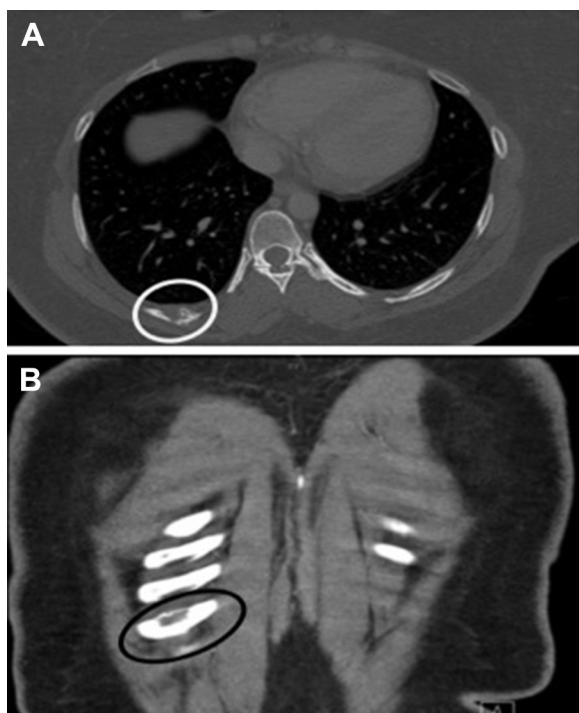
CT scan of the thorax. (A) Axial and (B) Coronal images revealing an expansile lytic lesion (circles).
